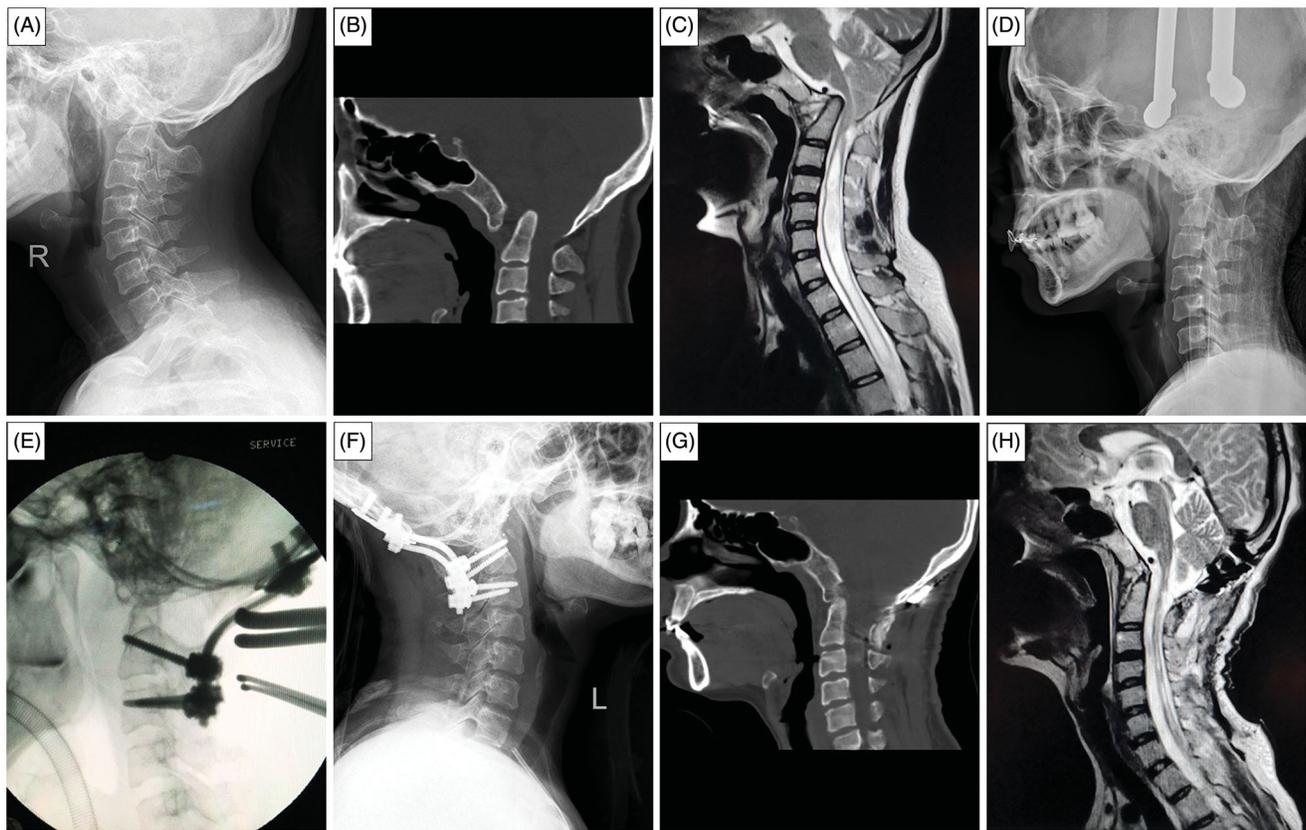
(A) 27-years-old female with BI/AAD and Klippel-Feil syndrome was treated by posterior atlantoaxial joint release, lever and distraction reduction, occipitocervical fixation. (A) Lateral X-ray showed BI; (B) CT median sagittal reconstruction presented significant atlantoaxial joint dislocation; (D) Preoperative MRI median sagittal T2W1 showed odontoid process intrusion into the foramen magnum and compression to CMJ; (E) CT median sagittal reconstruction showed the partial reduction of the odontoid after a large weight of the skull traction (1/4BW); (F) Intraoperative fluoroscopy presented AAD partial reduction under anesthesia and large weight skull traction (1/3BW); (G,H) Intraoperative atlantoaxial joint release, lever reduction, implantation of 12mm cage with autogenous bone into atlantoaxial facet joint and occipitocervical fixation was performed; (I) Postoperative lateral X-rays of the cervical spine showed good internal fixation position; (J) Postoperative CT median sagittal reconstruction showed odontoid process migration outside from the foramen magnum and full reduction of AAD; (K) Postoperative MRI median sagittal T2W1 showed the elimination of CMJ compression.
